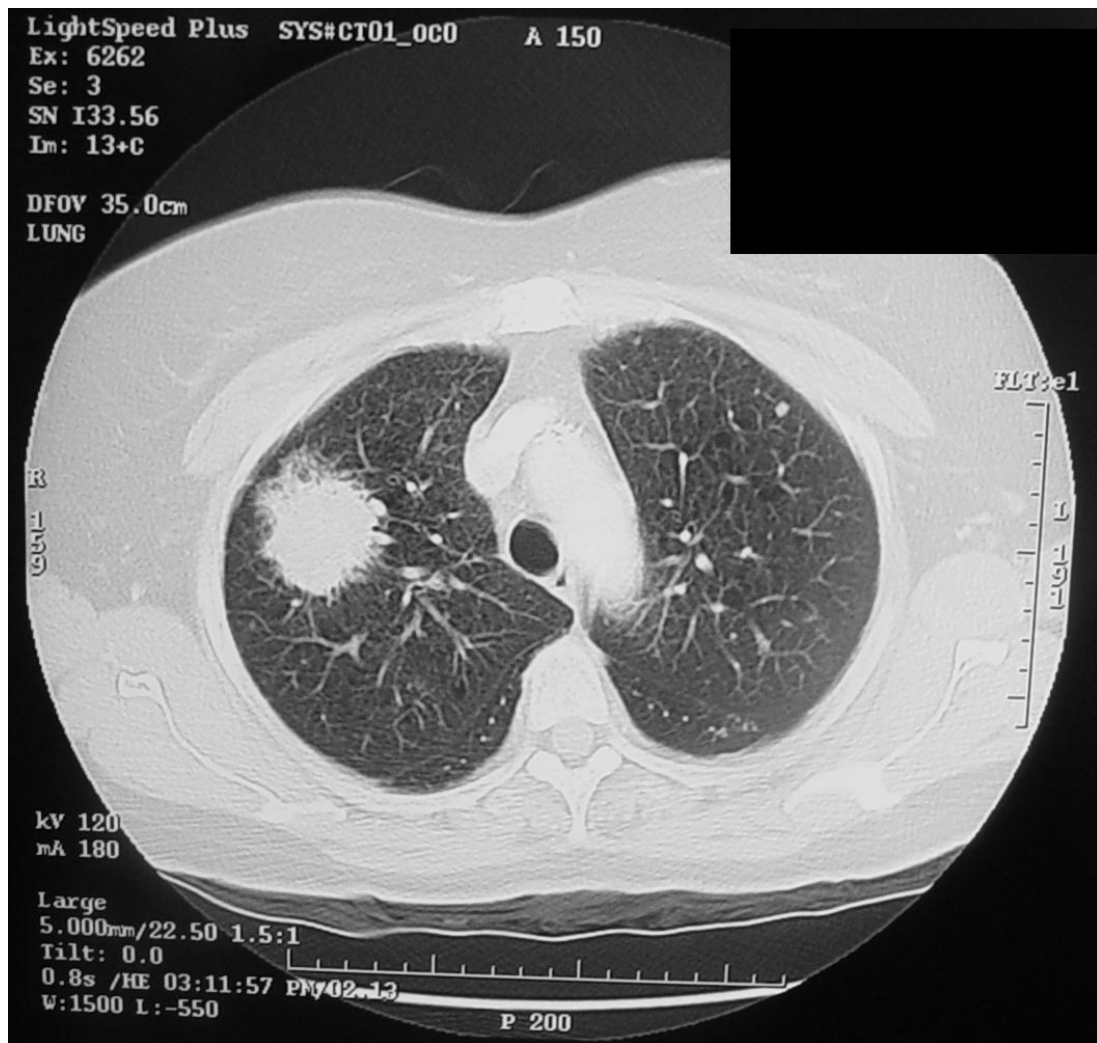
A cross-sectional CT image delineating a lesion in the upper zone of the right lung, subsequently confirmed to be cancer.
